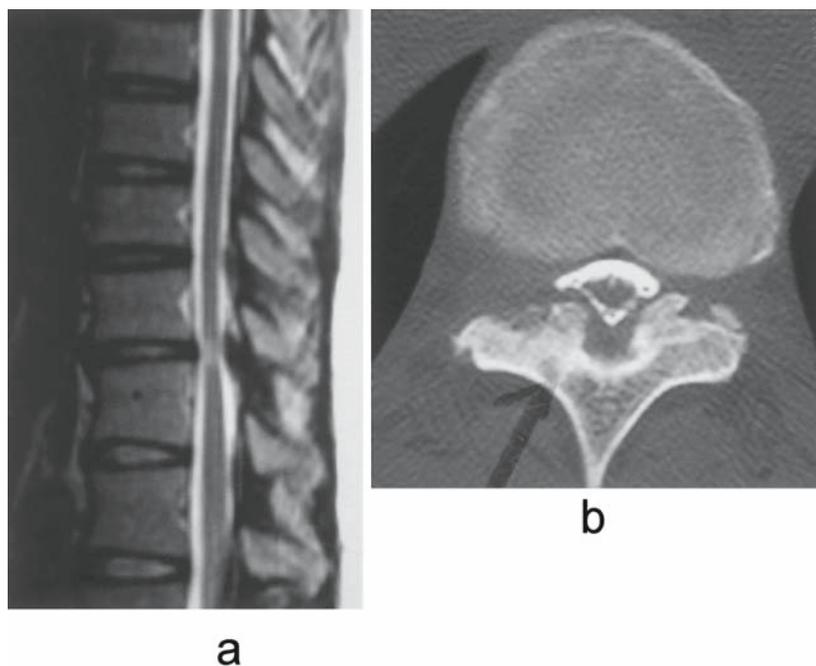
A 47-year-old woman with ossification of the ligamentum flavum (OLF) at T11–T12. She had muscle weakness in the right anterior tibial muscle and numbness in the right lower leg. She also had difficulty walking. a Magnetic resonance imaging (MRI). b CT myelography
